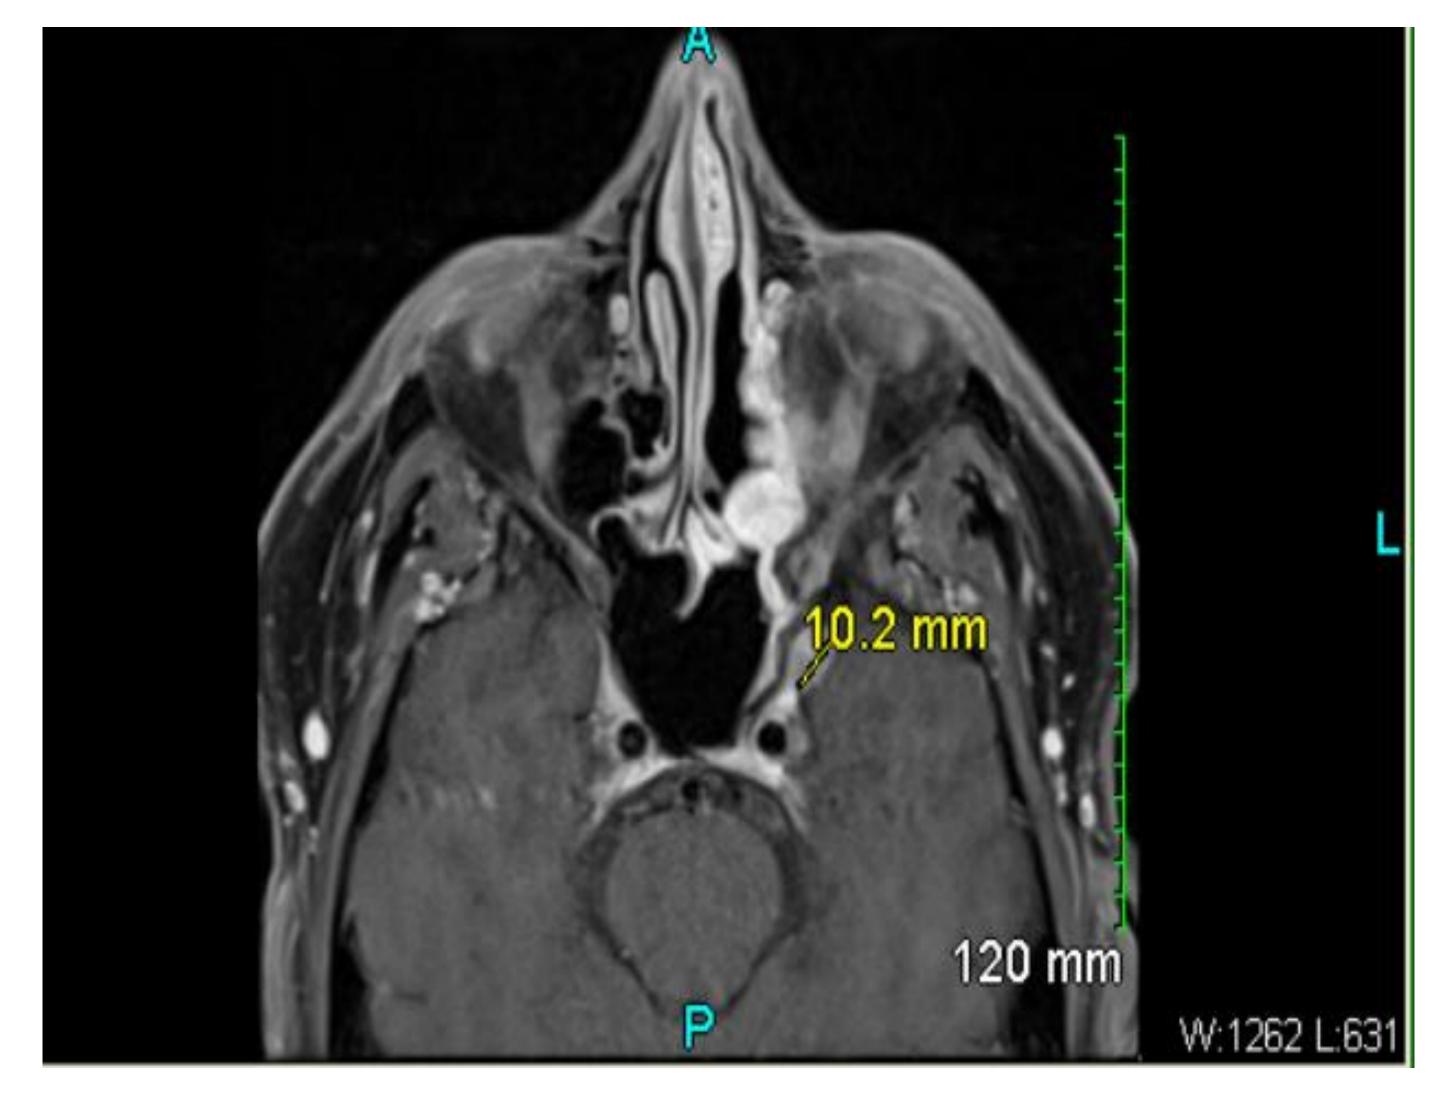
MRI of brain and face after treatment
